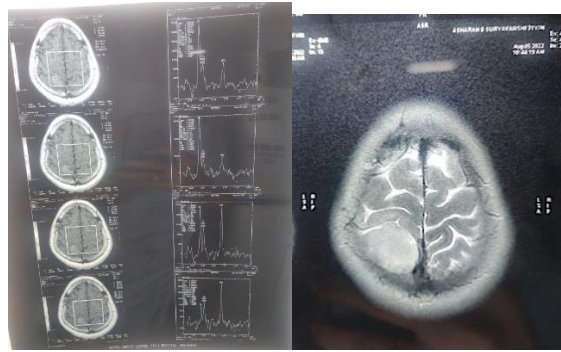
Pre-operative MRI Right Fronto-parietal tumor Near M1 area
